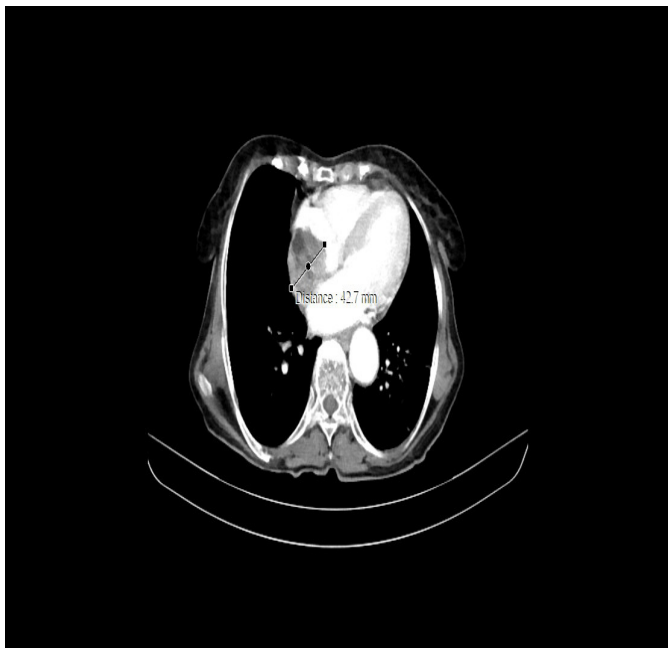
Thoracic CT, objectifying the intra OD mass of 42.7 mm (blue arrow). Imaging Service CHU Ibn Sina.
